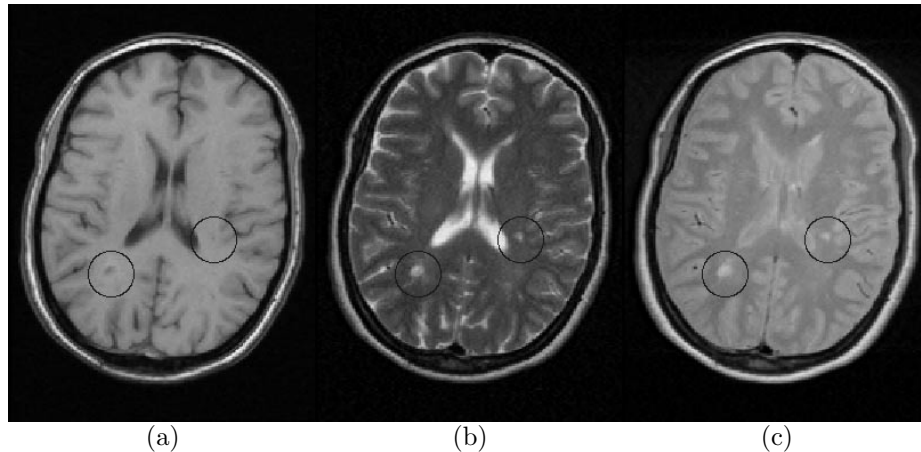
Example MR brain scan of a patient suffering from MS: T1-weighted (a), T2-weighted (b), and PD-weighted image (c). MS lesions are encircled.
